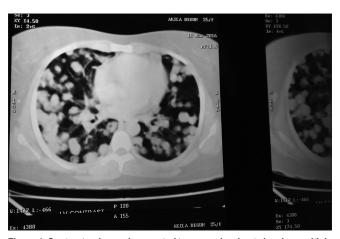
Contrast-enhanced computed tomography chest showing multiple bilateral "cannonball" pulmonary
